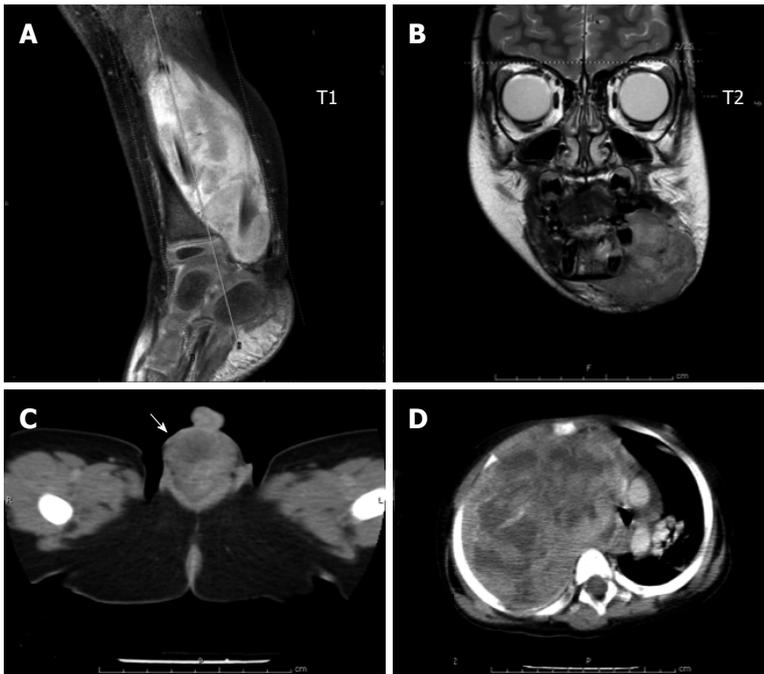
Radiographic images of common rhabdomyosarcoma. A: Extremity; B: Head and neck; C: Genitourinary (parasternal); D: Axial (intraabdominal).
